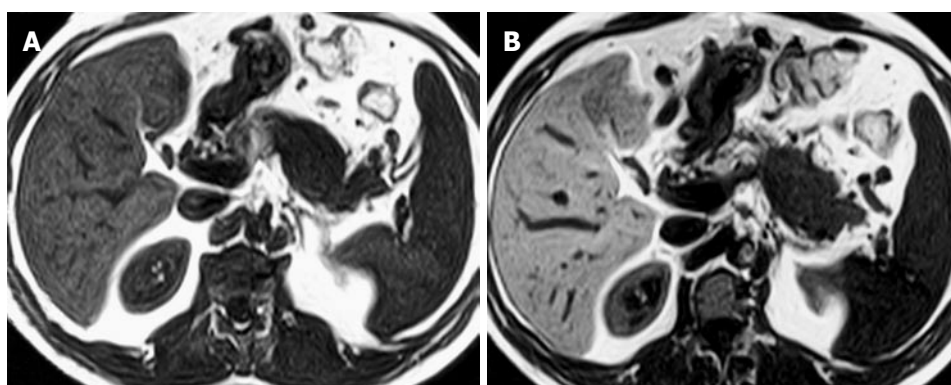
Unenhanced (A) and MnDPDP-enhanced (B) axial T1-weighted SE images showing better delineation of the tumor after MnDPDP infusion.
